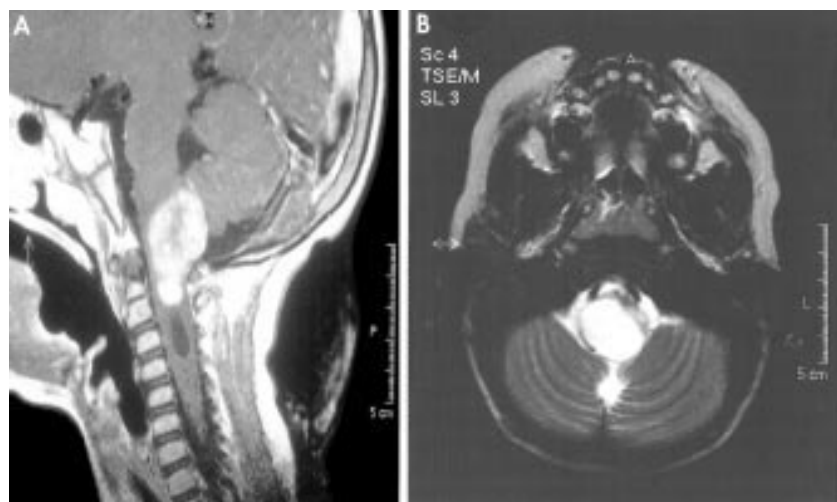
(A) T1 weighted sagittal magnetic resonance image (MRI) scan of the brain after gadolinium contrast, showing a space occupying lesion in the pons, extending to the medulla oblongata. Below the tumour a syrinx is present in the cervical myelum. (B) T2 weighted transverse MRI scan, showing extension of the tumour to the right cerebropontine angle.
